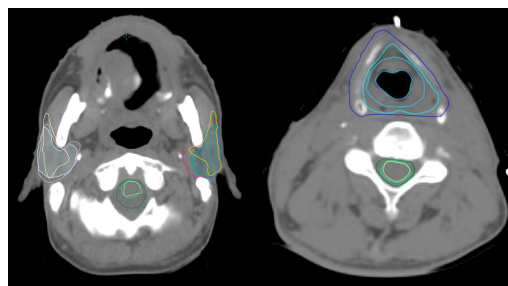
Example of auto-segmentation uncertainties of two software compared with manual reference delineations in 11OARs HN, projected on an axial CT slice.
